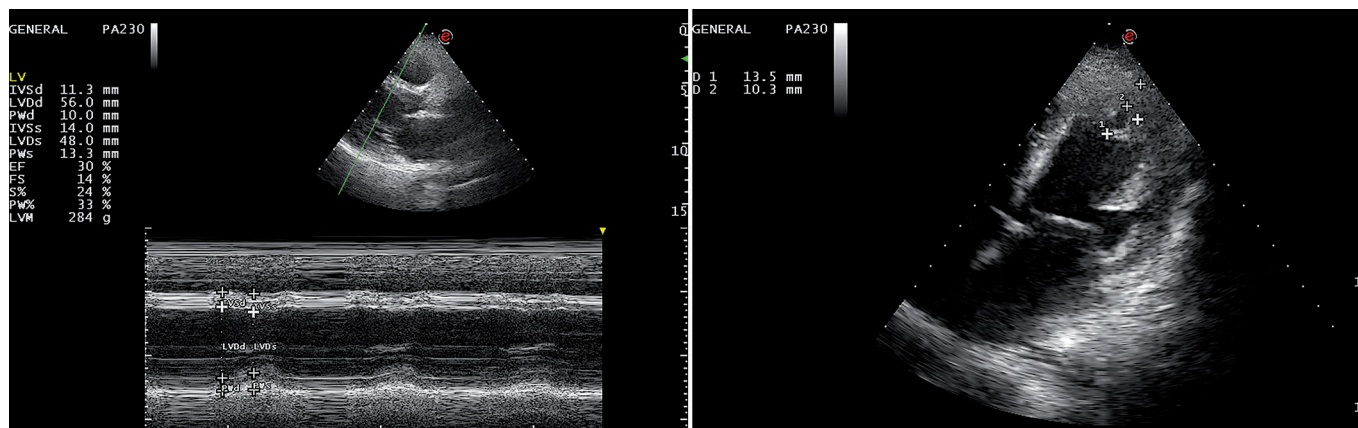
Transthoracic echocardiogram with slightly dilated left ventricle, ejection fraction = 30%. Unconvincing findings for left ventricle non-compaction.
